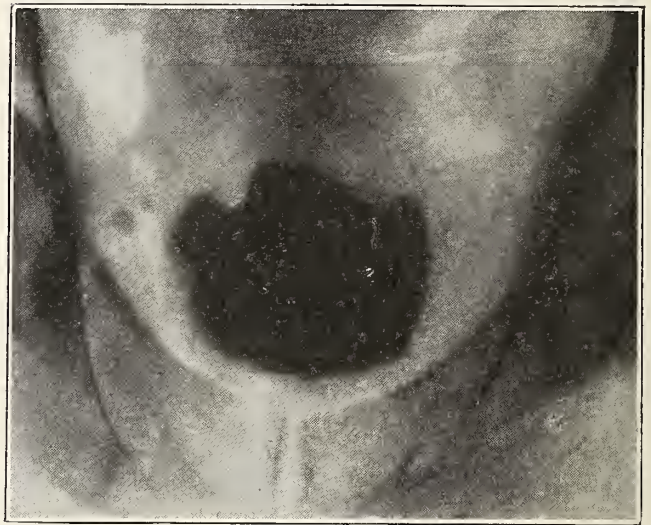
View of bladder partly filled with solution opaque to x-ray. Note the diverticula on right and left lateral walls respectively (own case).
